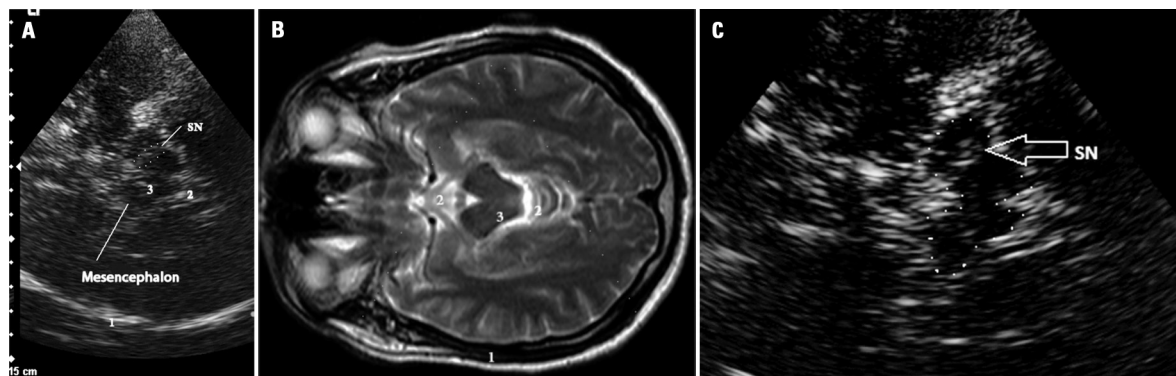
Mesencephalic images on Transcranial Sonography (TCS) and Magnetic Resonance (MR). [A] TCS performed in the mesencephalic scanning plane using the Acuson X300 (Siemens, Germany). TCS is performed through the temporal window, parallel to the orbitomeatal line. The hypoechoic butterfly-shaped mesencephalon is clearly depicted surrounded by the mesencephalic cisterns. Dotted line: ipsilateral normoechoic substantia nigra (SN). [B] MR image (T2 FAST), similar axial plane (not the same person). [C] Hyperechogenic enlarged SN of a patient with Parkinson's disease. Dotted line: mesencephalon (zoomed image). (1) contralateral temporal bone, (2) basal cisterns, (3) mesencephalon.
